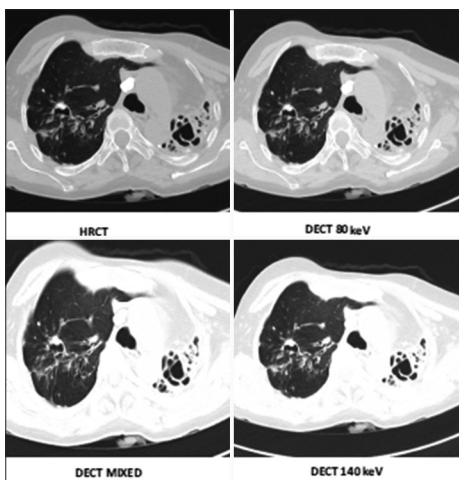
A 60-year-old man who presented with fever and cough with diagnosis of pulmonary tuberculosis. Axial high-resolution computed tomography (CT) and contrast-enhanced dual-energy CT (80 keV, mixed, and 140 keV) images showing cavity with a calcified foci within with surrounding nodules (few of these nodules are calcified), fibrosis in the right lung and collapse left lung with bronchiectatic changes and few calcified nodules. A large calcified lymph node is noted in the right paratracheal region.
